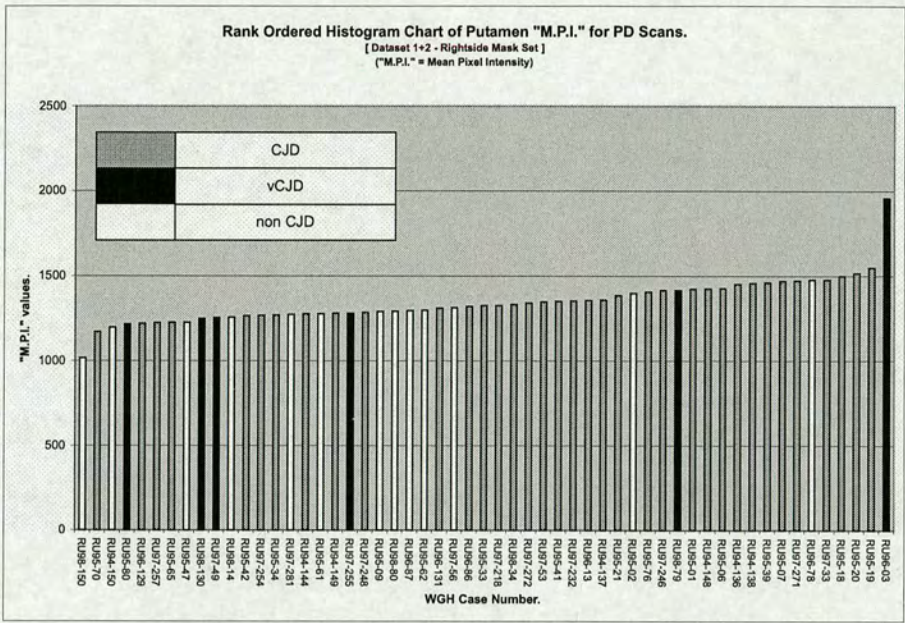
Bilateral Symmetry Tests: Rank ordered histogram of the Putamen "M.P.I." for the PD weighted MRI scan-data from the combined data-sets 1 & 2 generated using the rightside mask image-set.
